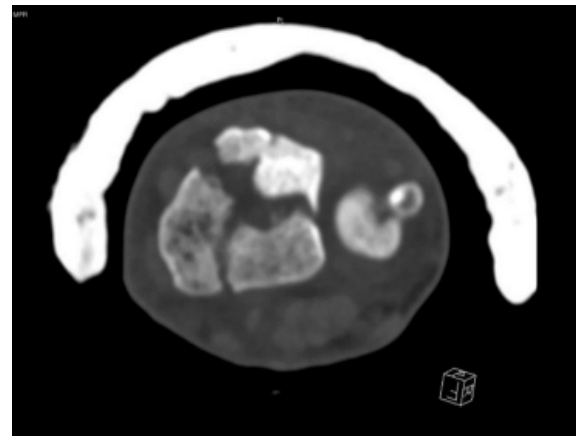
Cross-section of CT showing comminuted distal radial intra-articular fracture with the ulnar styloid avulsion fracture.
